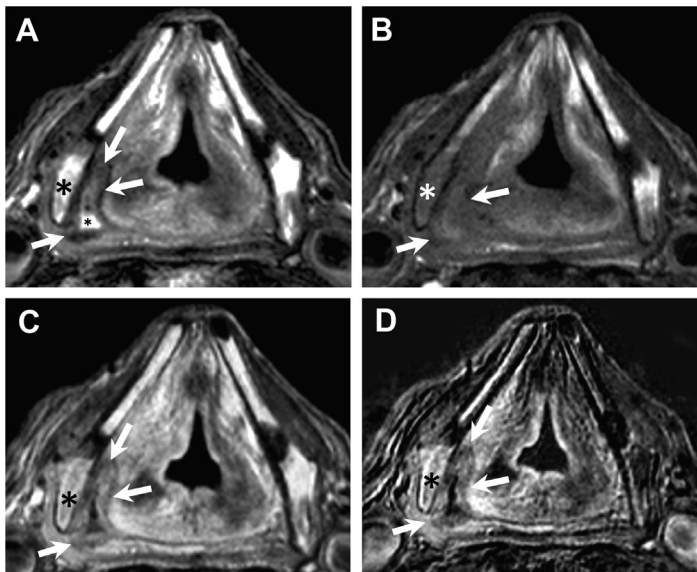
Characteristic MR imaging features of cartilage inflammation. Patient with an SCC of the right piriform sinus. Axial T2 (A), T1 (B), contrast-enhanced T1 (C), and subtraction image obtained by subtracting T1 from contrast-enhanced T1 (D) show a piriform sinus tumor invading the anterior wall, the angle, the lateral wall, and the posterior wall of the piriform sinus (*arrows* on all figure parts). The tumor has an intermediate signal on T2, a low signal on T1, and a moderate enhancement on contrast-enhanced T1. Note that the thyroid cartilage in the immediate tumor vicinity (*asterisk* on all figure parts) shows a much higher signal intensity on T2 than the tumor, a similar low signal on T1, and a much stronger enhancement on T1. The difference in enhancement patterns is particularly well seen in D (subtraction image). Small asterisk in A indicates fluid retention in the right piriform sinus.
